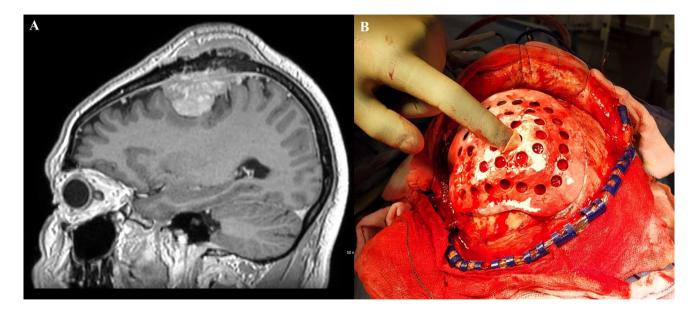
A A contrasted MRI brain showing a 52×34 -mm mass superior to the left frontal lobe which involved the overlying frontal and parietal bones and displaced the falx to the right. B Using the cutting
